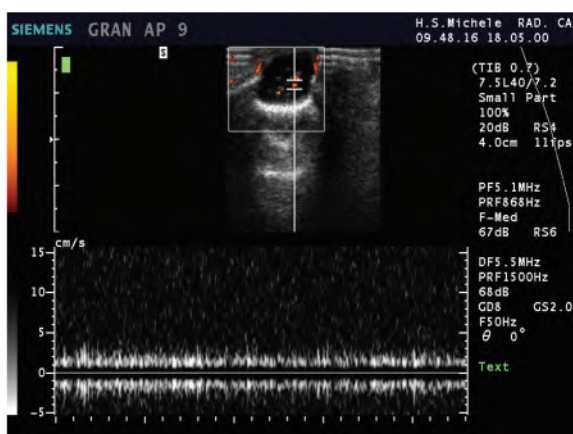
3 Image representing the echo color power Doppler applied to the echographic examination of a periapical lesion. On the upper right, the ultrasound image of the lesion is showed (framed). The colored spots represent the presence and direction of the blood flow (color Doppler). The intensity of the Doppler signal with its modification in time (cm/s) is represented in the lower part of the figure.
